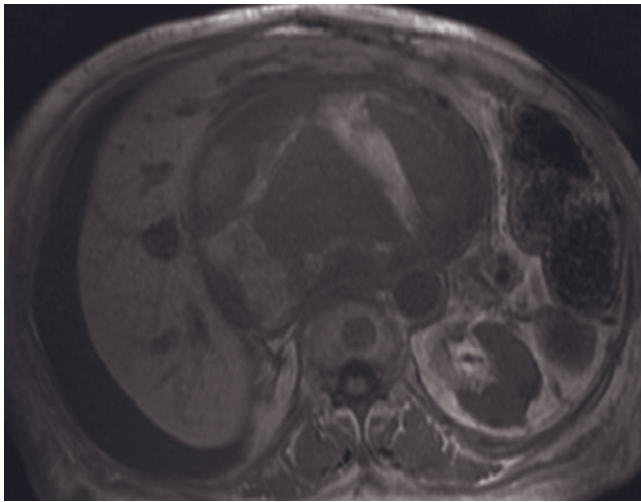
Gastrointestinal stromal tumor (GIST). Coronal (a) and transverse (b) T2-weighted SS-ETSE, immediate postgadolinium SGE (c), and 90-s postgadolinium fat-suppressed SGE (d) images. A large multilobulated tumor (arrows, a, b) measuring $18 \times 16 \times 13$ cm is shown arising from the gastric wall (open arrow, a, b). Multiple internal foci of high signal intensity are seen, representing areas of hemorrhage and necrosis. On the immediate postgadolinium image (c), the tumor enhances heterogeneously
